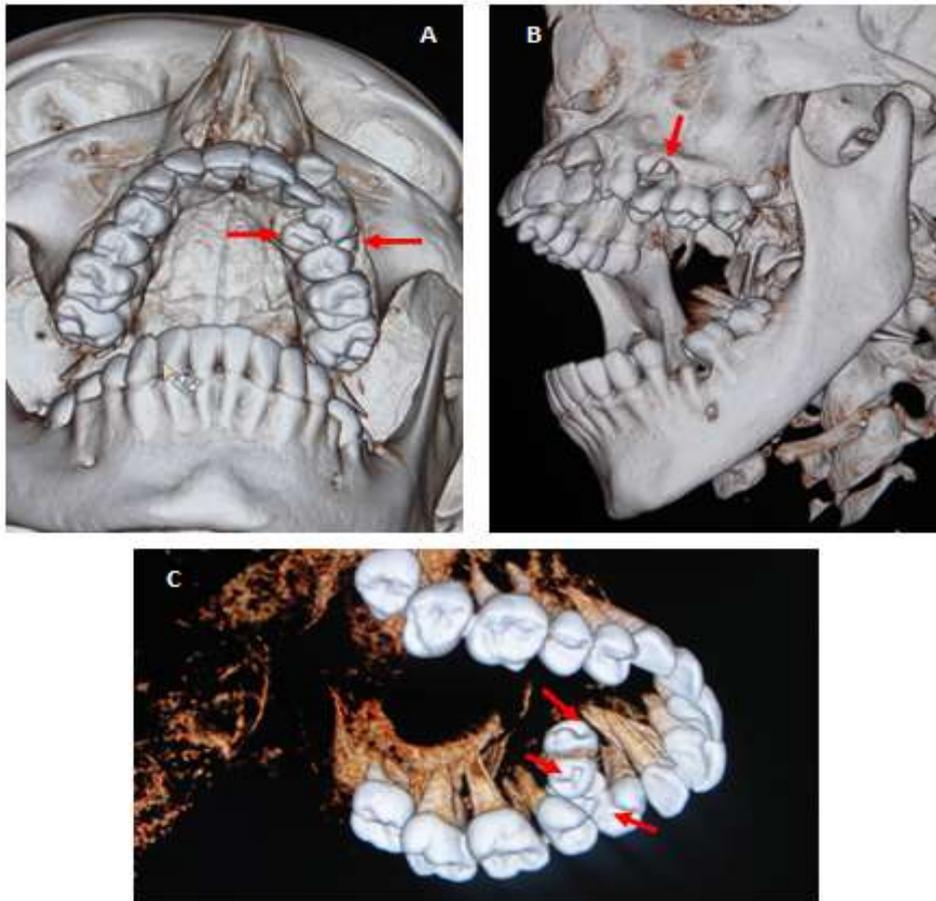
Dental 3D Software CT with multiplaner reconstruction of maxilla demonstrating a relationship between the left three superior premolar impacted supernumerary teeth (red arrows) with the other teeth caused the malocclusion, and crowding, for the same patient aged 20 years. (A) Occlusal view of maxilla, Two superior premolar impacted supernumerary teeth, Type II, supplemental shape, caused the malocclusion, and crowding. (B) Lateral view of left half of skull and jaws, one superior premolar impacted supernumerary teeth, Type I, supplemental shape caused the malocclusion, and prominence of gingival (red arrows). (C) Occlusal view of maxilla, accumulation of 3 ≤ number presented of superior premolar impacted supernumerary teeth (red arrows).
